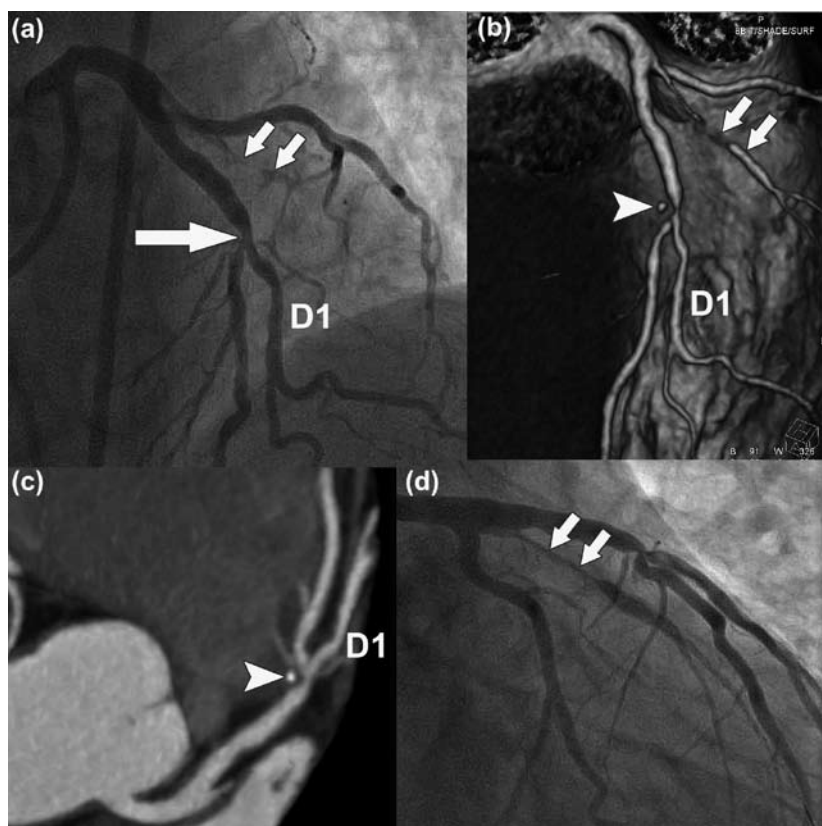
(a) Invasive coronary angiogram showing a significant bifurcation lesion (large arrow) of the left anterior descending coronary artery with the first diagonal branch (D1). Also note the limited contrast enhancement (small arrows) in what looks like a small side branch. (b) Three-dimensional reconstruction of the heart with CT showing the bifurcation lesion. The dense spot within the lesion (arrowhead) corresponds to calcification. The branch that was faintly visible angiographically, can now be clearly recognized without interference of overlapping vessels as the intermediate branch (arrows). (c) 3-mm thick maximum intensity projection clearly showing the calcified (arrowhead) and non-calcified plaque components causing the lumen narrowing. (d) After wiring the intermediate branch its true dimension can be well appreciated (arrows).
